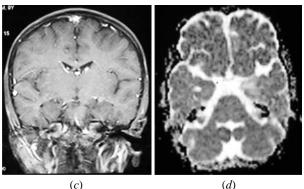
MRI brain of the patient done 19 days after onset, demonstrating hyperintensities in the left hippocampus and medial temporal lobe on T2-weighted (a); and FLAIR sequences (b), with no contrast enhancement in post gadolinium images (c), suggestive of limbic encephalitis. The lesion appears bright on the ADC map (axial) (d) suggesting there is no evidence of restricted diffusion.
